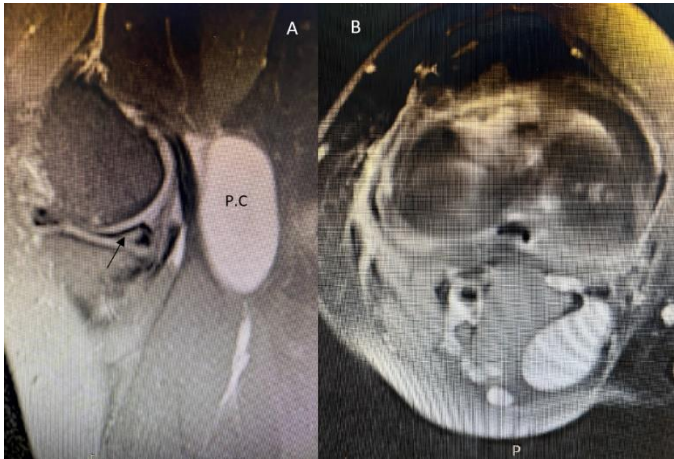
(A) A sagittal magnetic resonance imaging (MRI) scan of a popliteal cyst (P.C) in T2 view, showing the posteromedial portion. The arrow indicates the meniscal tear. (B) Axial magnetic resonance imaging of a popliteal cyst.
